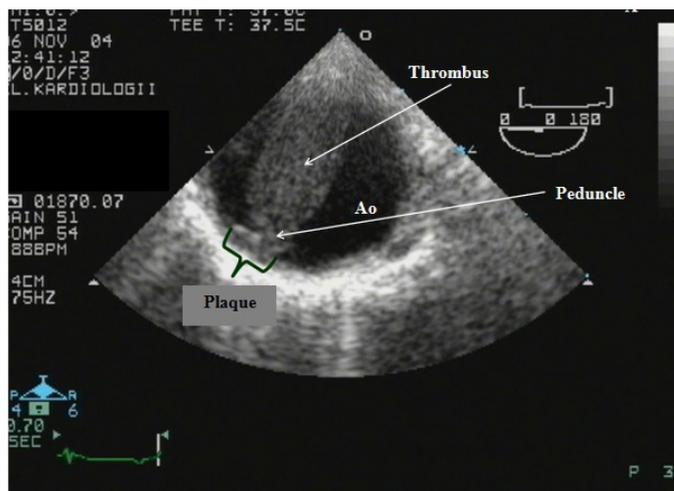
Transesophageal echocardiography – short axis, 0°. Presence of the floating thrombus (length – 32 mm, diameter – 12 mm) in the distal part of aortic arch with high, depending on blood flow, mobility.
